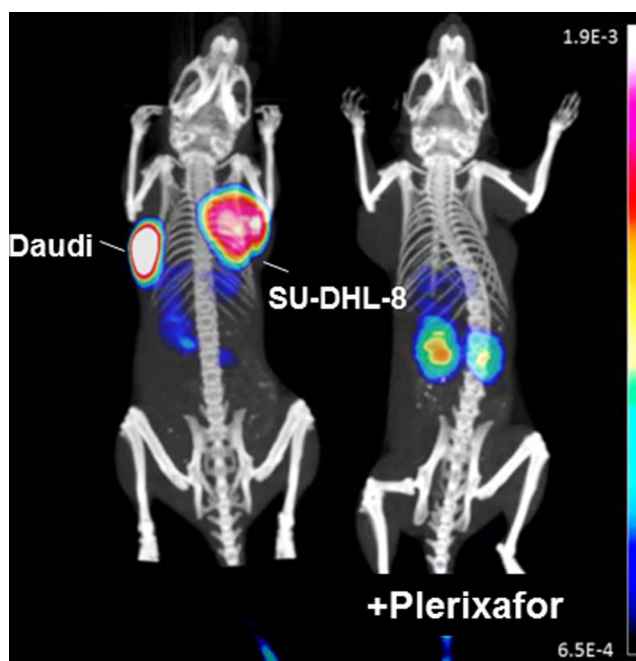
Coronal μ PET/CT maximum intensity projections depict CXCR4-expressing Daudi and SU-DHL-8 lymphoma xenotransplants after injection of [^{68}Ga]Pentixafor (left). For competition (right), [^{68}Ga]Pentixafor was coinjected with the CXCR4 specific ligand AMD3100 (non-specific bladder activity blanked out). This research was originally published in J Nucl Med 2011;52:1803–10 [13].
